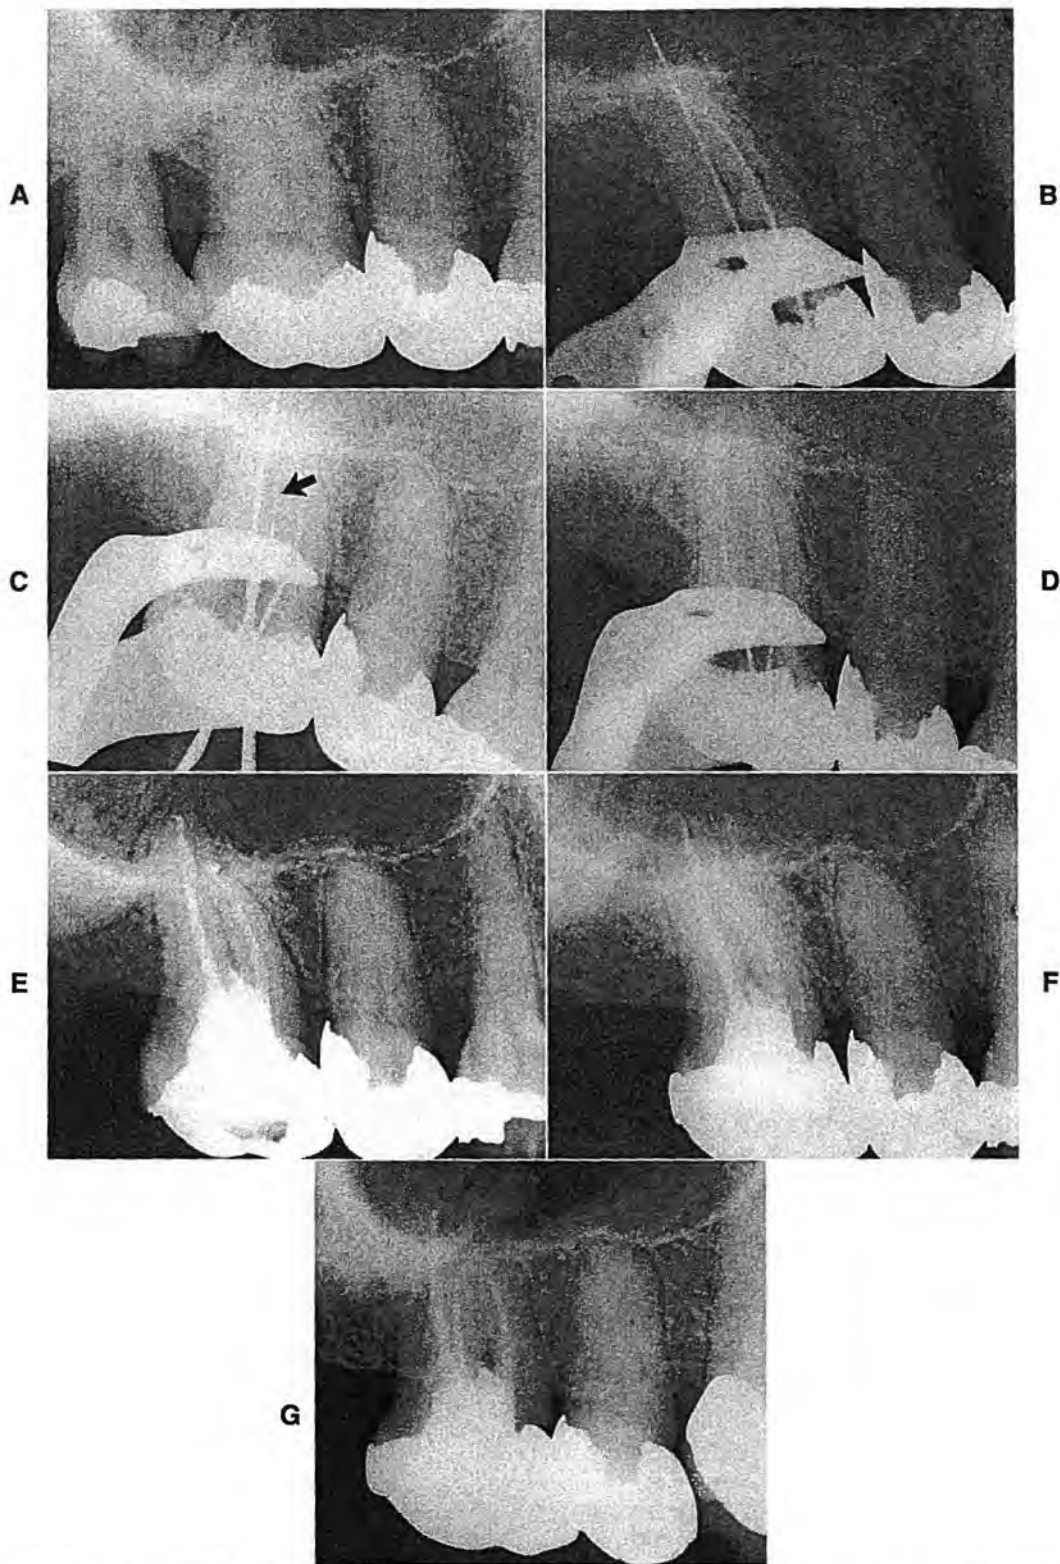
Perforation of chamber floor repaired with ZOE. A, Preoperative radiograph of maxillary molar area. Patient complained of severe pain to both hot and cold temperatures, and it was impossible to tell which molar was causing the problem. Because of the severe periodontal condition of the more posterior tooth, it was decided to have that tooth extracted in the hope it was responsible. After the extraction the pain persisted, so the other molar was scheduled for endodontic treatment. B, The palatal canal was located first, and then one buccal canal was found, indicated by this film of files in place in the palatal and mesiobuccal canals. More preparation was performed to locate the distobuccal canal. C, I thought that I had located it, so I placed files and took this radiograph. The file with the arrow had perforated the floor of the chamber rather than being placed in the distobuccal canal. D, The distobuccal canal was located slightly more to the distal. Files were placed into the canals to keep them patent during the repair. The orifice portion of the perforation was slightly widened with an inverted cone bur. Then the entire chamber floor was packed with ZOE. When the cement had set, the files were removed and patency verified. E, Treatment was completed, with canals filled with laterally condensed gutta-percha. F, Three years after original treatment. The tooth is comfortable, no pocket can be probed, and the area has retained a normal condition. G, Thirteen years after original treatment, all tissues appear normal.
